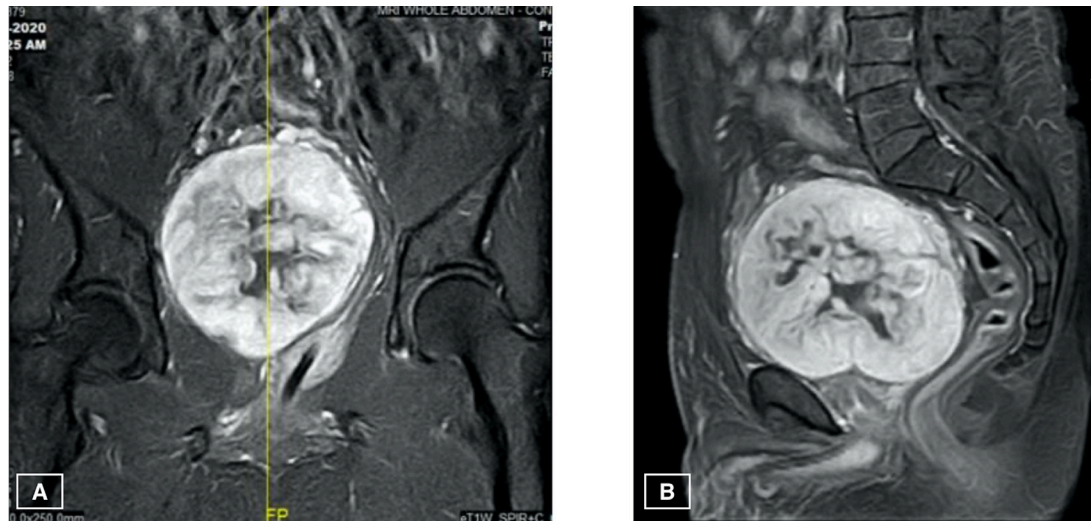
T1WI-FS postcontrast. (A) coronal view showing the mass pushing the prostate and pars-prostatic urethra, catheterised, to the left and, (B) sagittal view showing clear borders of the mass from the prostate, bladder and rectum. T1WI-FS, fat-suppressed T1-weighted imaging.
